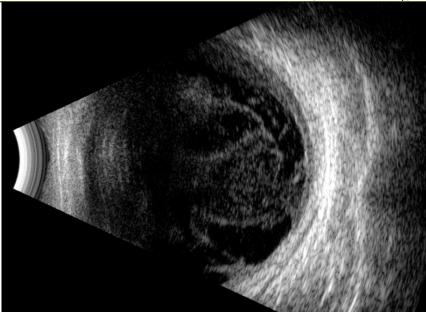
B-scan ultrasonography of the left eye demonstrating marked vitreous opacities consistent with vitritis; no chorioretinal mass or retinal detachment is observed
